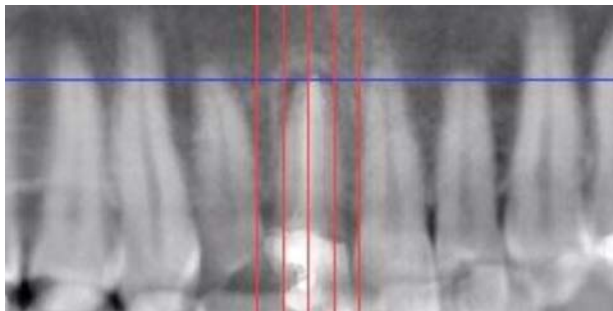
Cone beam computed tomography "scout" film shows apical disease. Cross-sectional images are used to determine whether immediate implant placement can be considered.
